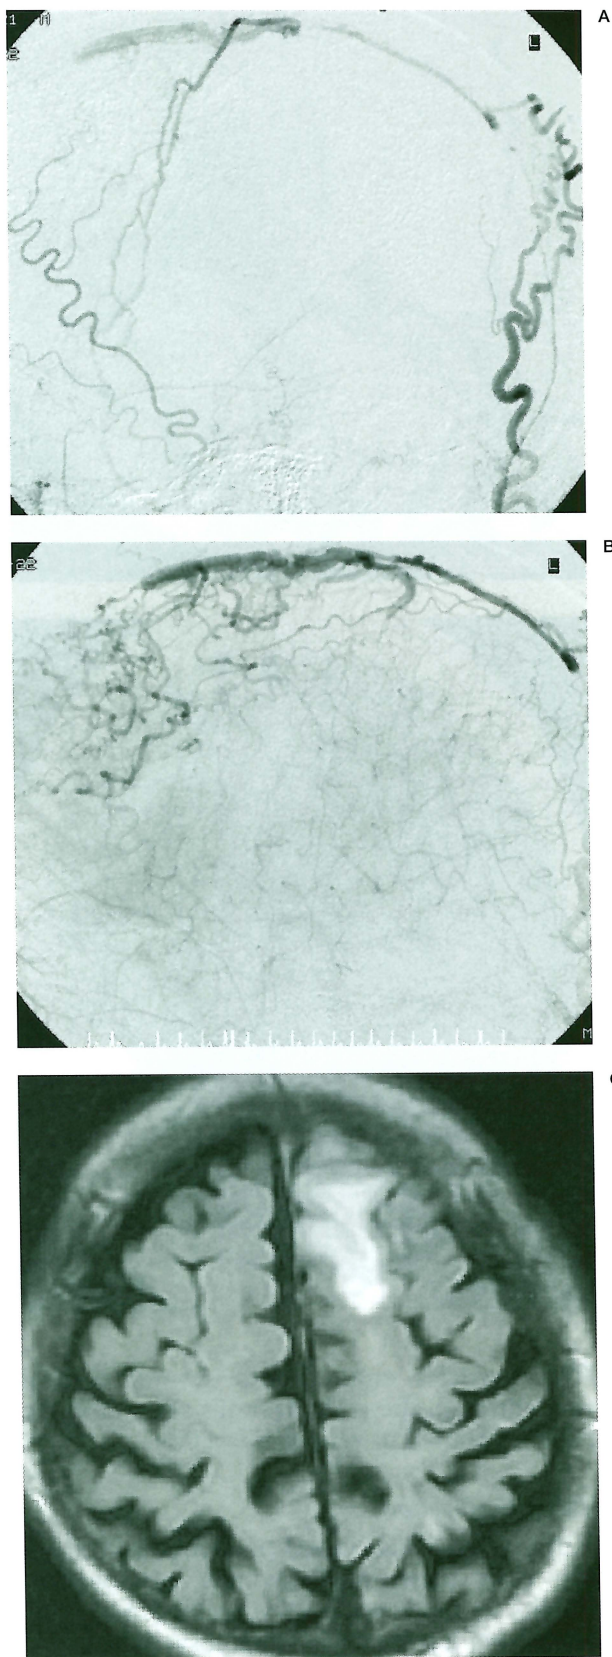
A) Left external carotid angiogram (lateral view, arterial phase). The SSS dural AVF was fed by the middle meningeal and occipital arteries. B) Left external carotid angiogram (lateral view, venous phase). Cortical venous reflux was recognized. C) Post-embolization MRI (FLAIR image). Venous infarction was recognized in the left frontal lobe.
